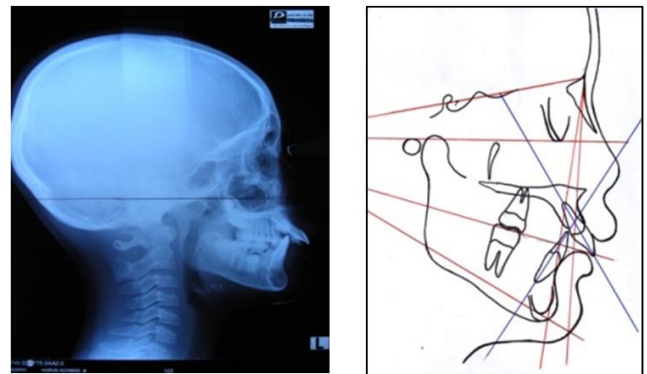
Cephalometric radiograph, tracing before treatment.
